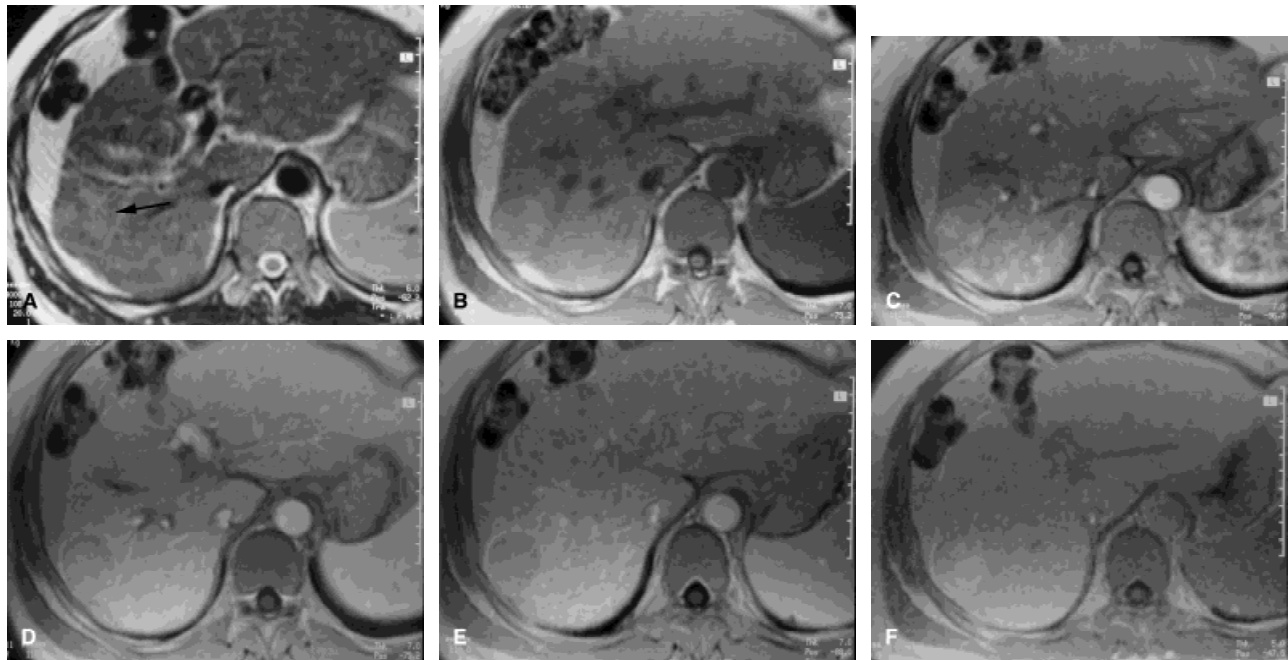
High-grade dysplastic nodule in a 56-year-old man with cirrhosis. a: TSE T2-weighted transverse MRI shows a round isointense nodule with some slightly hyperintense areas in the right lobe (arrow). b: On precontrast T1-weighted GRE transverse images the lesion is hyperintense. During dynamic imaging with bolus administration of Gd-BOPTA (GRE transverse T1-weighted), the lesion shows inhomogeneous enhancement in the arterial phase (c) to become hypointense in the portal venous (d) and distribution phase (e), with a peripheral capsule. f: In the hepatobiliary phase (GRE transverse T1-weighted) 2 hours after Gd-BOPTA injection the lesion is hyperintense.
